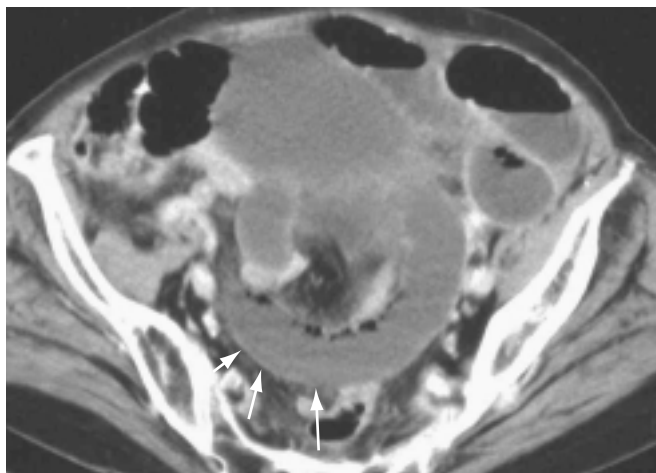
SBO from adhesions with necrosis. Postcontrast CT of the abdomen showing wall thinning of the involved bowel loop (arrows).
